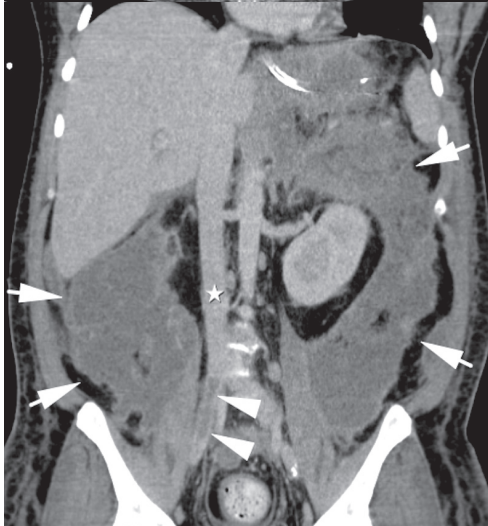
A 43-year-old woman with thrombus in the right iliac vein during the course of acute necrotizing pancreatitis. Coronal reformatted contrast-enhanced CT depicts a large filling defect in the right iliac vein (arrowheads), diagnostic for deep vein thrombosis in a patient with necrotizing pancreatitis and extensive retroperitoneal collections (arrows). White star denotes the inferior vena cava. To prevent pulmonary embolism anticoagulant therapy is mandatory.
